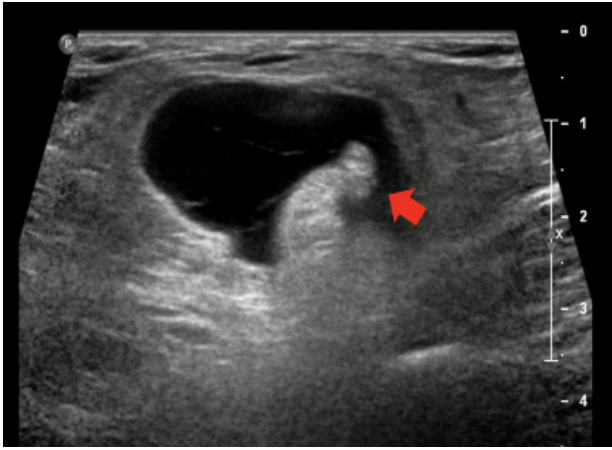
Ultrasonography findings of the inguinal mass. Femoral hernia.
